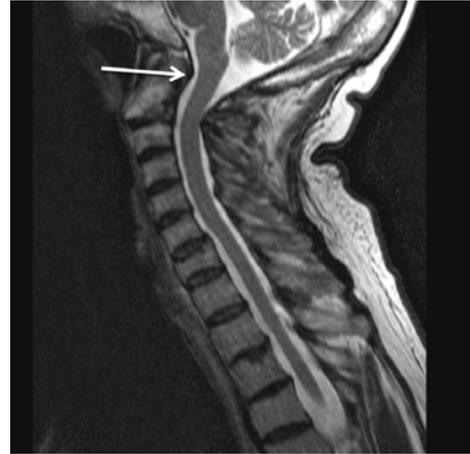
A T2 sagittal magnetic resonance imaging of the cervical spine showing basilar invagination (arrow).
